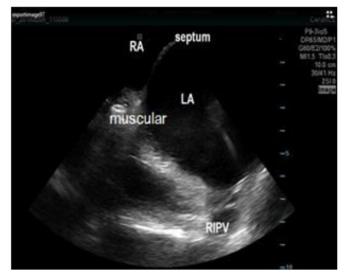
Intracardiac echocardiography. In this view the interatrial septum can be seen in the same plane with the right inferior vein. In this plane is not safe to perform transseptal puncture as it is too posterior with a theoretical risk of puncturing the posterior wall of the left atrium.
